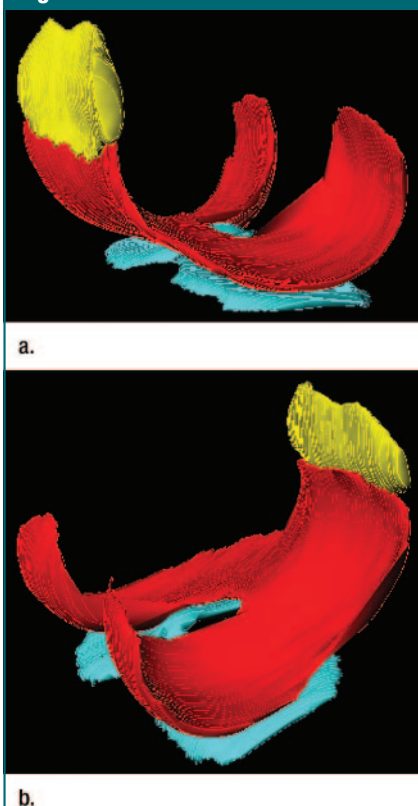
Example of cartilage segmentation performed by using fluctuating equilibrium MR imaging in healthy 32-year-old male volunteer. Cartilage surfaces on the femur (red), patella (yellow), and tibia (blue) are all well seen.
